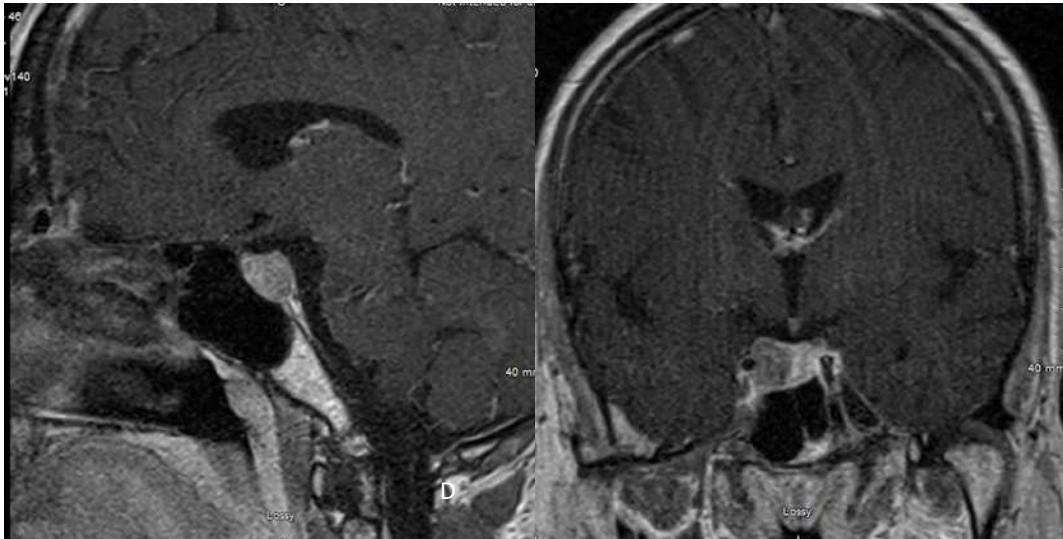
Postgadolinium T1-weighted MR images in the sagittal (*left panels*) and coronal (*right panels*) planes. A and B: Images from 2012, demonstrating a pituitary macroadenoma with suprasellar extension and abutting right ICA. C and D: In 2021, the macroadenoma has significantly reduced in size, with decrease in suprasellar component.
